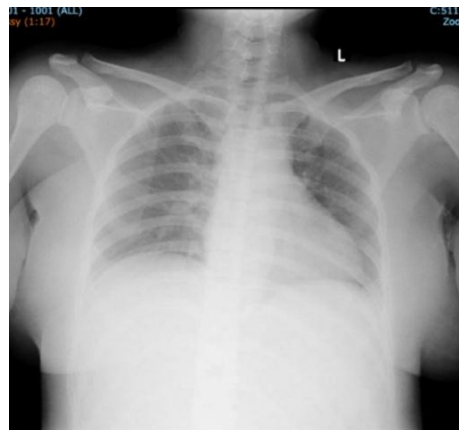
Chest radiograph (PA view) demonstrating normal cardiac and pulmonary silhouettes.
